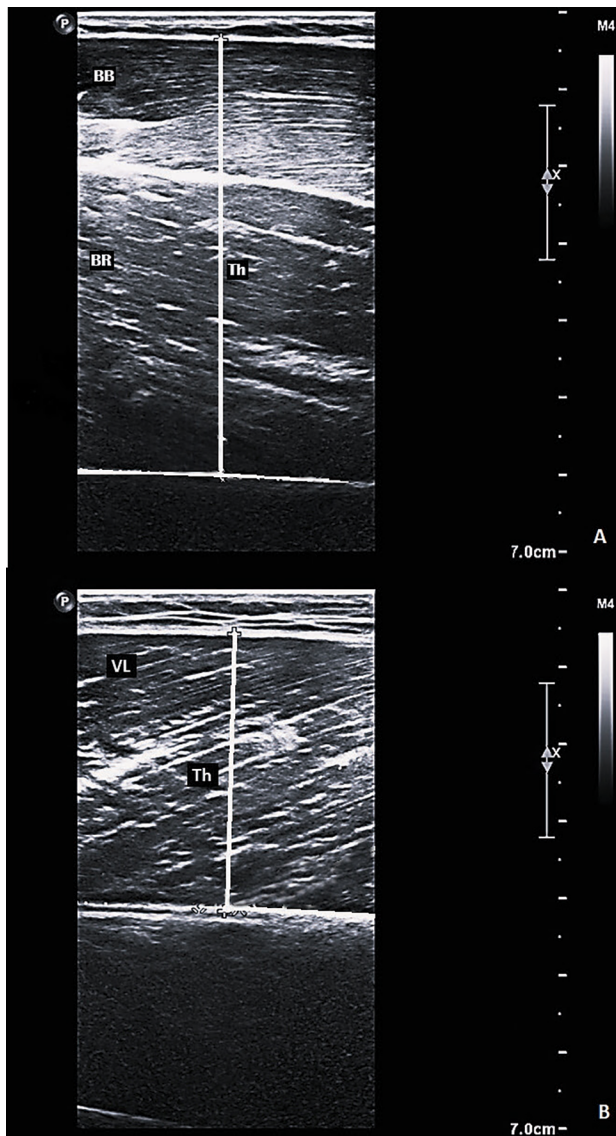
Sagittal ultrasound images of elbow flexors' (A) and vastus lateralis (B) muscle thickness.
